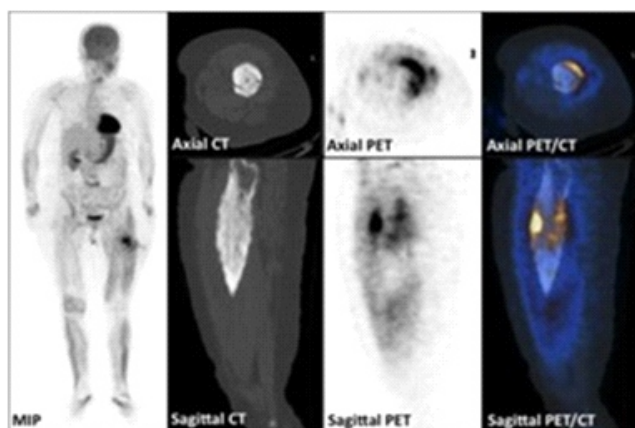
A 63 year old woman with persistent low limbs pain. Fluorine-18-FDG PET/CT: unexpected and atypical pathological uptake in the left femour (SUV max 8.7) and mild uptake in the surrounding soft tissues (suspect for osteosarcoma) (guiding biopsy). Biopsy on the lesion detected by ^{18}F -FDG PET/CT: osteopetrosis [8].
